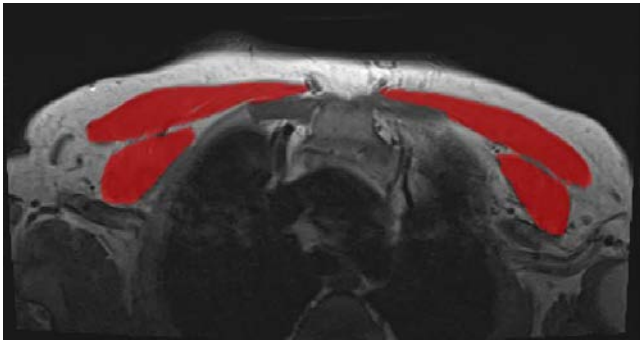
A 48 year- old, newly diagnosed breast cancer Turkish patient. The pectoralis muscle was identified at the level of the sternal angle of Louis used as a bony landmark. The pectoralis muscle (major and minor) area was countered bilaterally (red area) on axial pre-contrast T1-weighted MRI.
